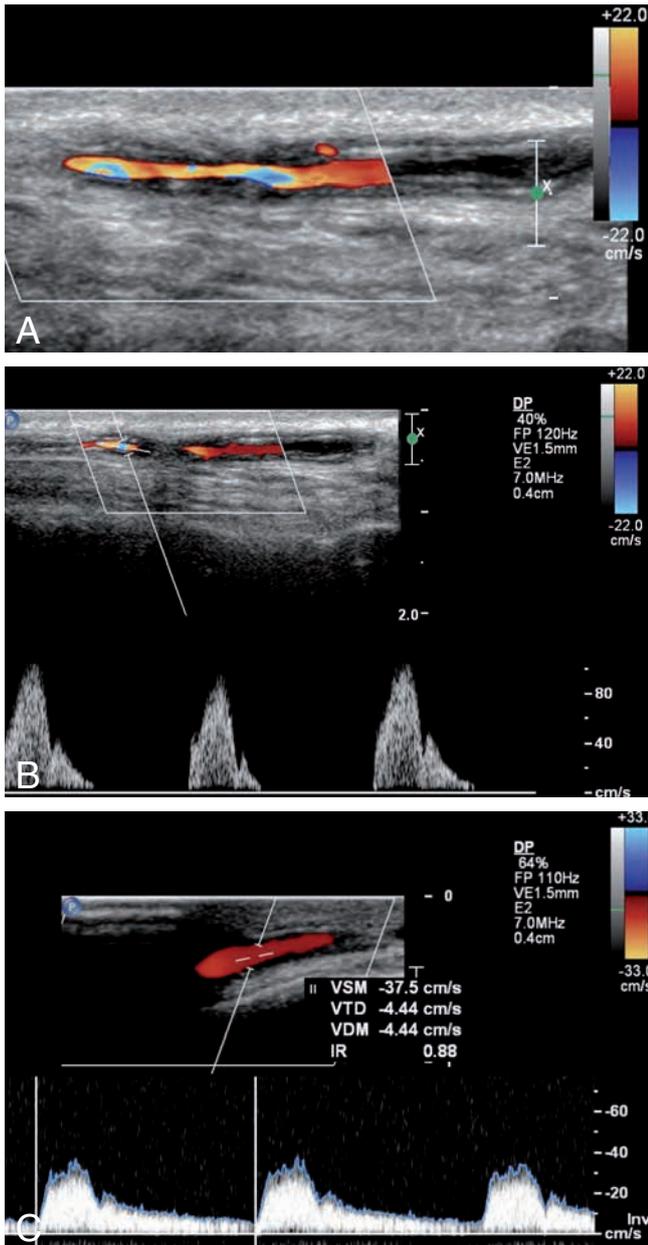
Multifocal areas of aliasing in Doppler imaging (A) with acceleration in spectral Doppler (B). These areas represent multiple stenosis. On (C) the post-stenotic arterial waveform in the distal segment of frontal ramus of temporal artery.
